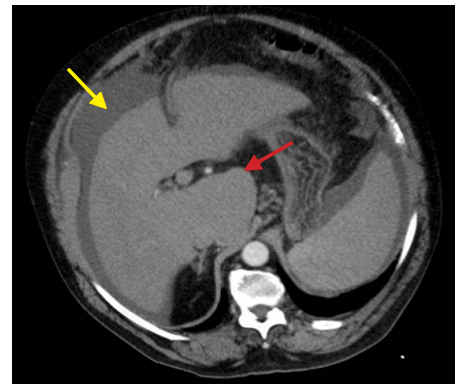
Computed tomography of axial plane in portal phase. Cirrhotic liver: lobed contours (yellow arrow) and moderate hypertrophy of the caudate lobe (red arrow)
